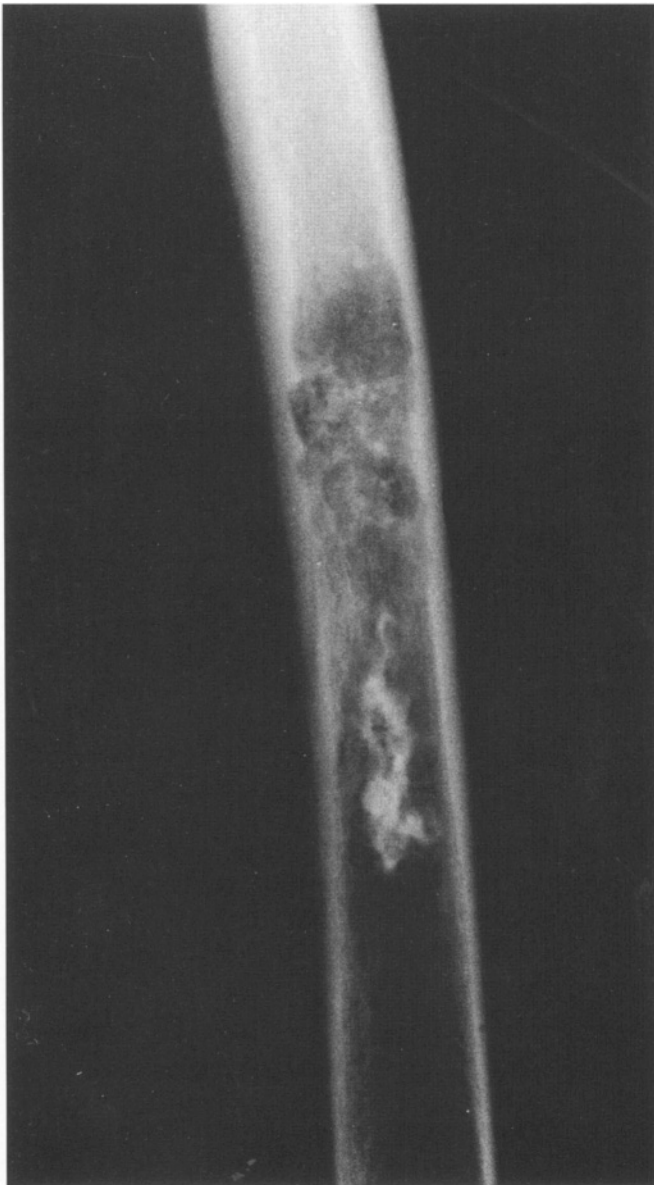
Plain radiograph of the femoral shaft, showing a central chondrosarcoma, presenting as a well-defined lytic lesion with a sharp transition zone, calcifications, and endosteal scalloping.
